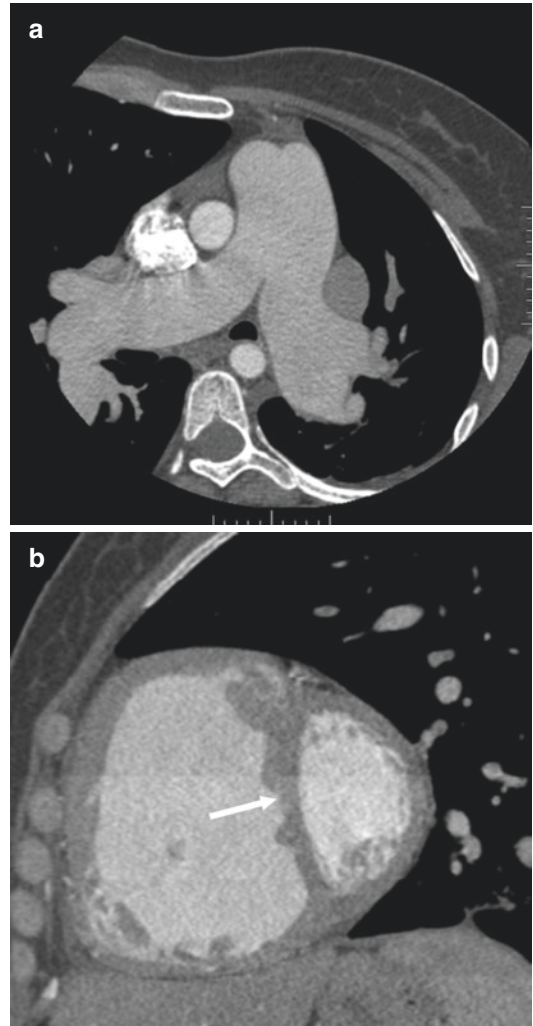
Pulmonary hypertension. (a) Axial CTA image demonstrates severe dilation of the main, right and left pulmonary arteries, consistent with pulmonary hypertension. (b) Sagittal contrast enhanced CT image in another patient shows flattening of the interventricular septum in systole, also a feature of pulmonary hypertension
